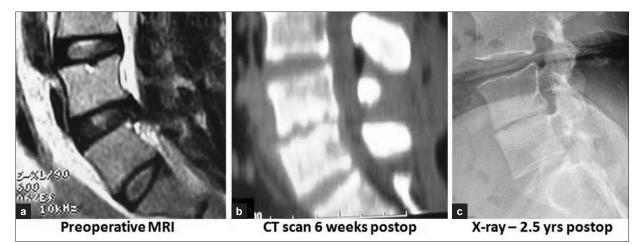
(left to right) Preoperative T2 sagittal MRI (a), sagittal reconstruction CT scan (b) and lateral skiagram (c) at 2.5 years showing good healing with conservative treatment
